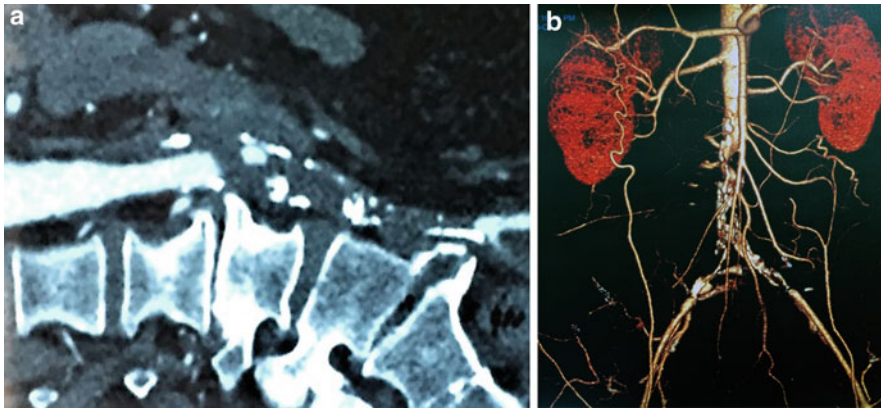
CT Angiogram examples of an occluded aorta and iliac arteries in sagittal CT and 3D reconstruction modes
